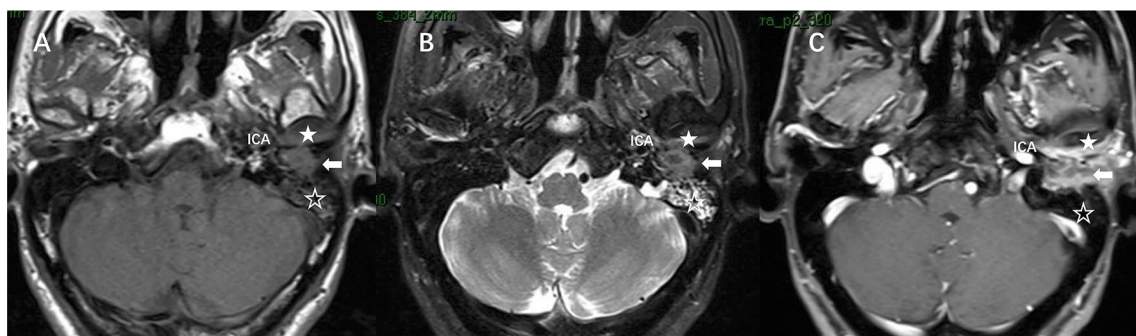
A Patient with T4N0M0 SCC in the EAC. Temporal bone MRI T1WI (A) shows an isointensity signal (arrow) in the EAC. T2WI (B) shows an isointensity signal (arrow) in the EAC. T1WI
